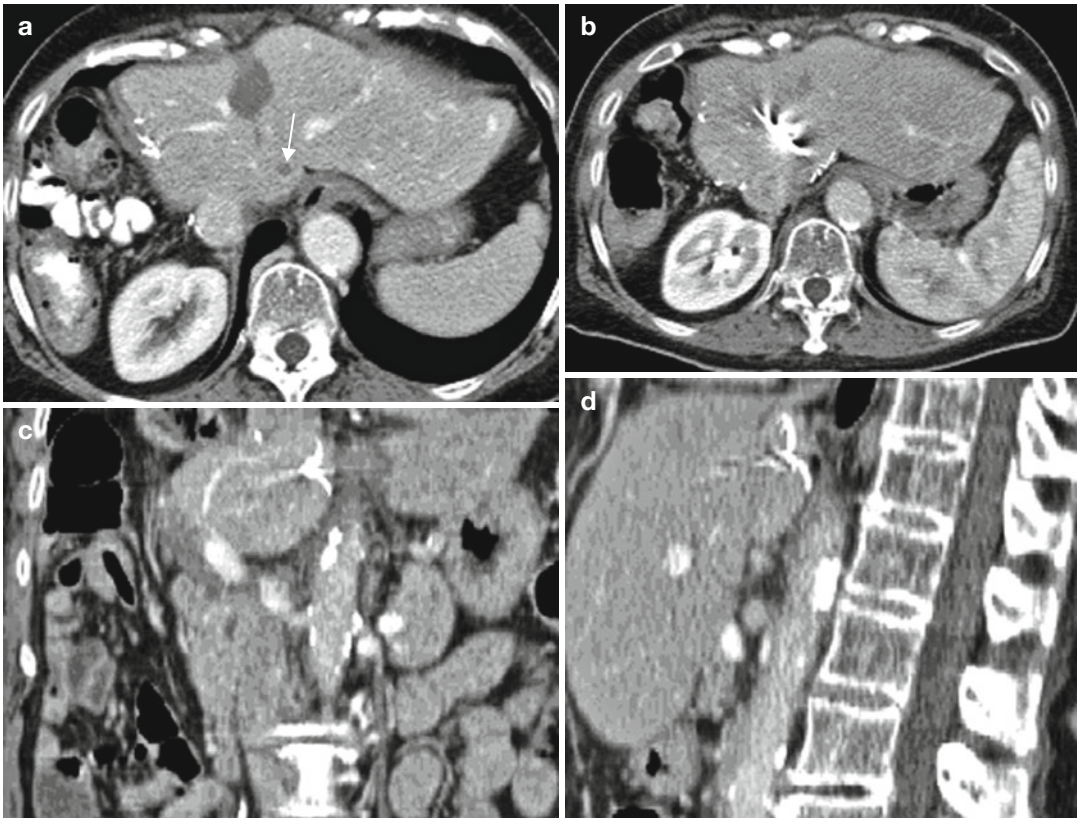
Angulated outplane anterolateral approach to a suspected small focal liver lesion in segment 8. Biopsy revealed colorectal metastasis. Preinterventional enhanced CT (a) demonstrates a small focal hypodense
